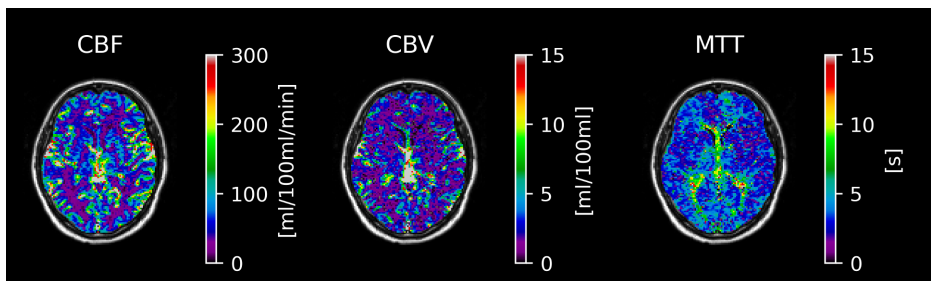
Parameter maps of CBF (left), CBV (center) and MTT (right) resulting from a standard DSC-MRI acquisition of a healthy elderly subject, overlaid on a fluid attenuated inversion recovery image. CBF and CBV have been scaled such that CBV in white matter is 2 ml/100ml.
